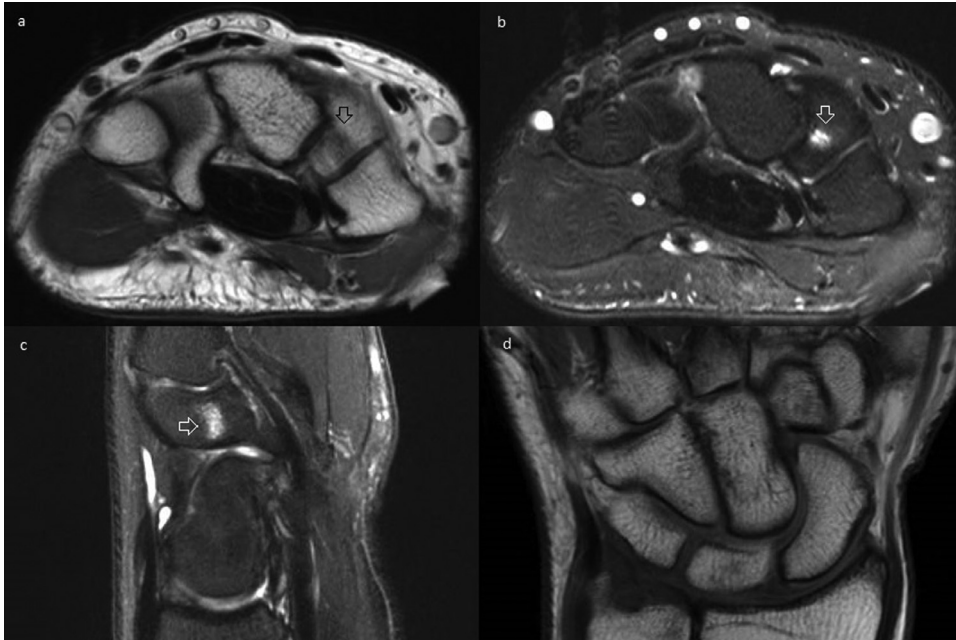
Axial proton density image (a) demonstrates a focal coronally-oriented band of low signal with corresponding edema on T2, fat-saturated images in both axial (b) and sagittal planes (c), more focal than the other demonstrated fractures. The fracture is difficult to see on coronal T1-weighted images, and there is no additional evidence of fracture (d).
